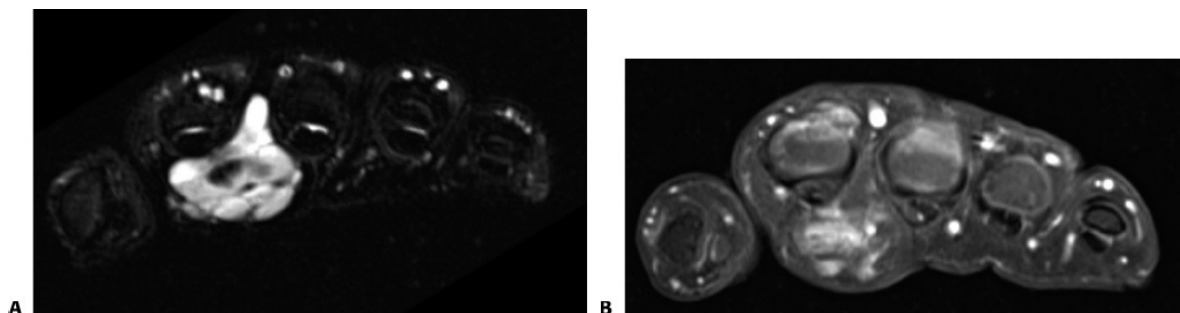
• T2-weighted (A) and T1-weighted postgadolinium (B) MRI images of the lesion.
